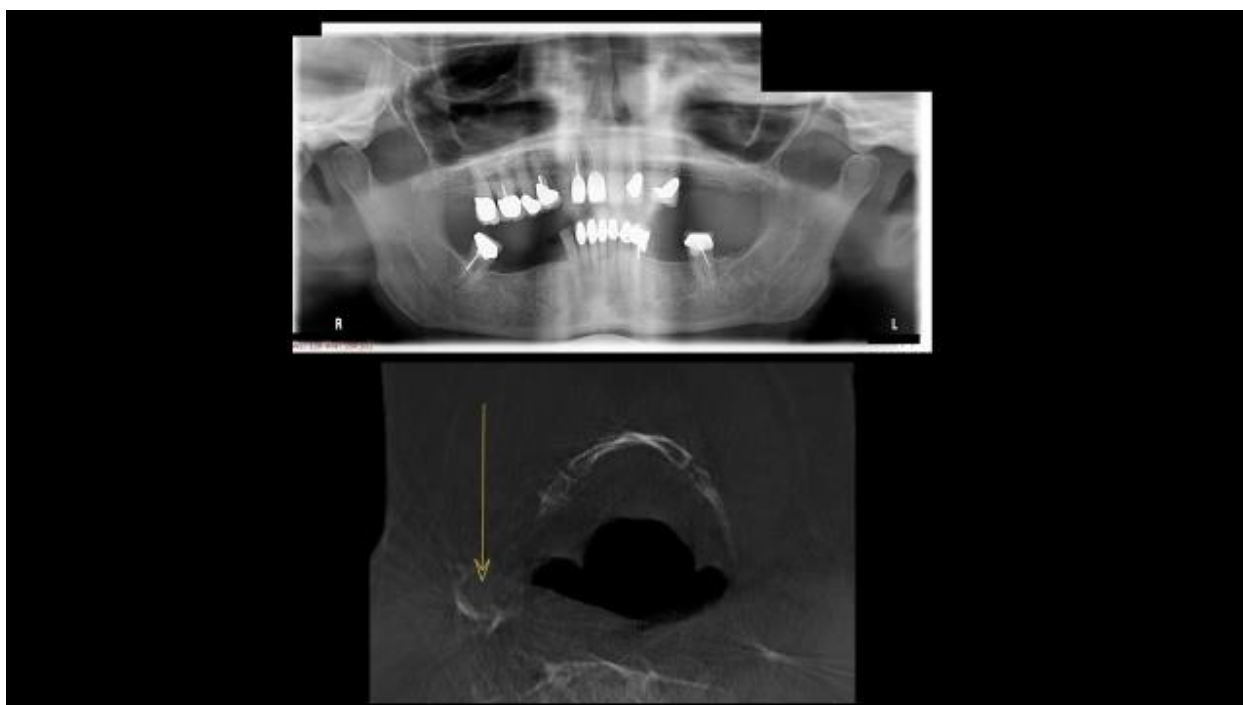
Carotid Atheroma CBCT (bottom) not visible on PAN (top)
